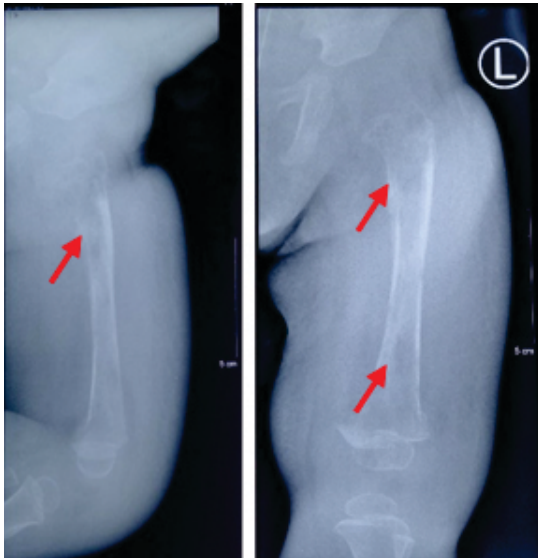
AP / Lateral left femur X-ray showed destructive osteolytic lesion on left femur.
